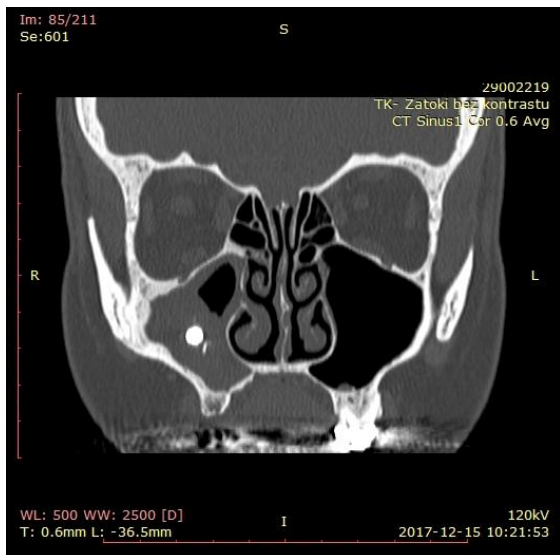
X-ray of the head – before surgical treatment.
